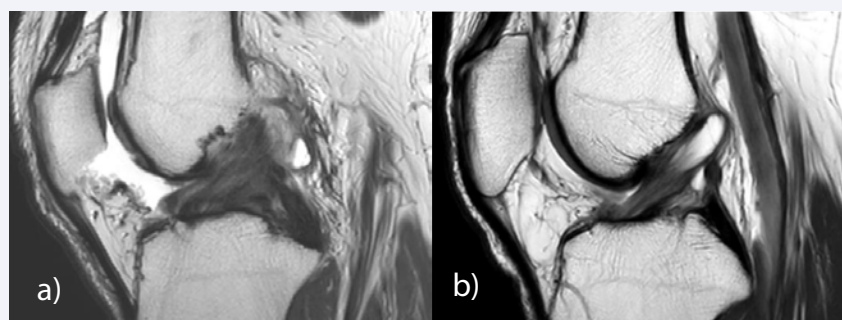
Imaging pitfalls in diagnosing ACL tears. (A) The ACL is thickened and ill-defined with increased signal intensity interspersed among visible intact fibers on sagittal T2-weighted image ("celery stalk" sign), resulting from mucoid degeneration of the ACL. (B) A fusiform, lobulated lesion with fluid-equivalent signal intensity is noted interspersed within the ACL fibers. A ganglion cyst may be mistaken for a torn ACL.
